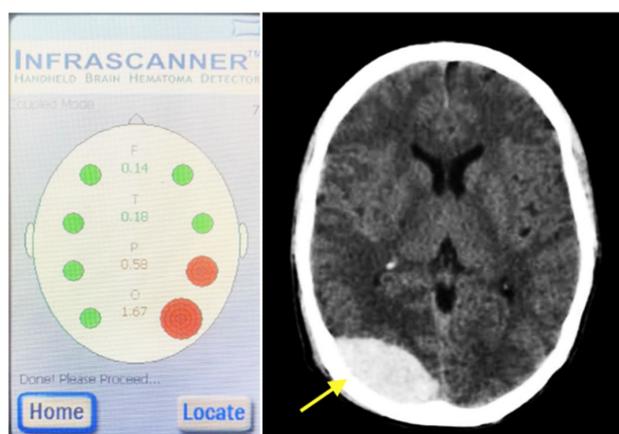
Positive InfraScanner measurement (red circles on the left side of the image) and the corresponding CT scan presenting a right-sided occipital extradural hemorrhage (yellow arrow). Note that the InfraScanner view is oriented from the top of the patient’s head (as if looking down from the crown), while CT images are usually interpreted from the feet upward. This explains why the same lesion appears on opposite sides in the two modalities.
